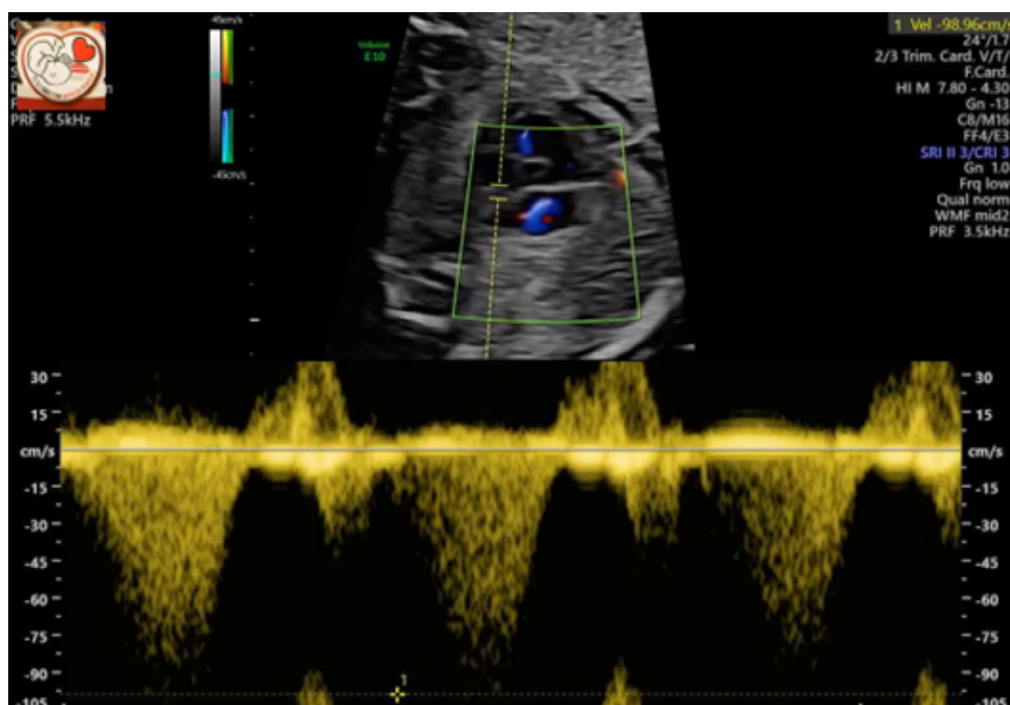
Fetus with HLHS with mitral regurgitation with a blood flow of 98.96 cm/s. Ultrasound image from the Prenatal Cardiology Department at the Institute of the Polish Mother's Memorial Hospital
